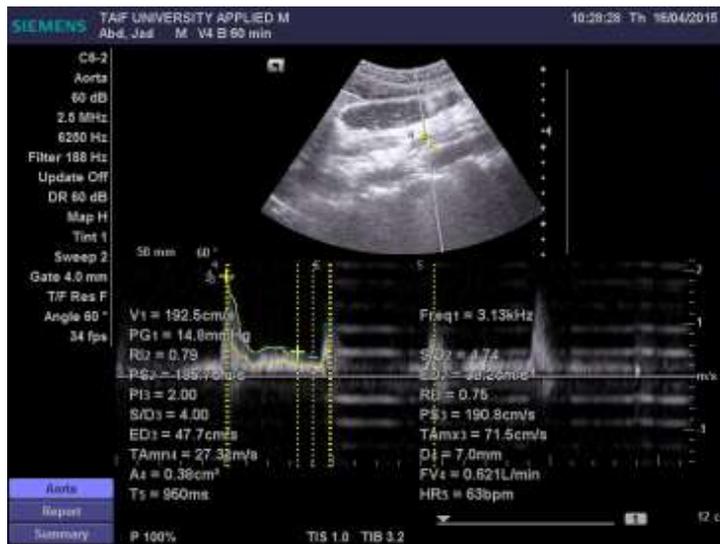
Duplex sonogram of the SMA showing heart rate
